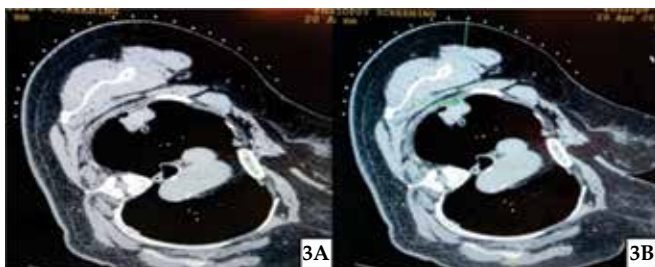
Computed tomography of the chest showing location of the mass for biopsy with the help of paper pins and (B) measurement of length and depth for biopsy needle between two most appropriate paper pins head.
